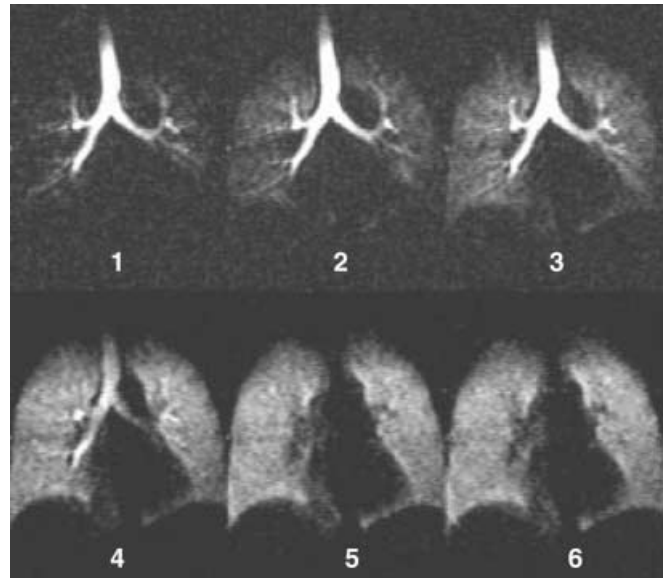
Dynamic ventilation He-3 MRI after inhalation of hyperpolarized He-3 gas in a 27-year-old volunteer shows a rapid and homogeneous filling of the airspaces bilaterally
